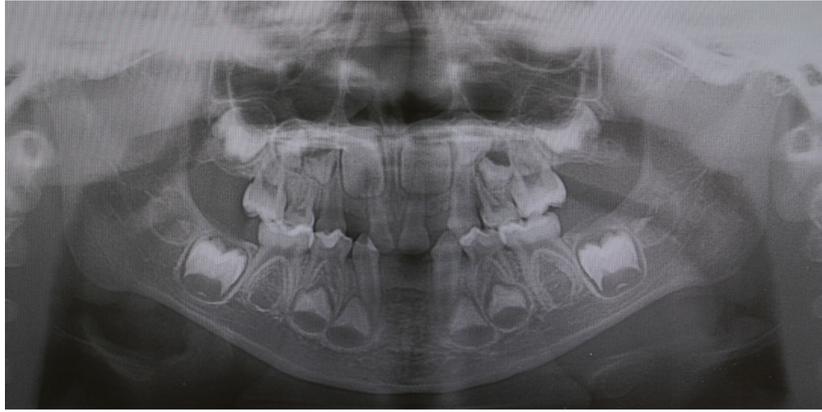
Panoramic radiograph taken at the initial visit.
